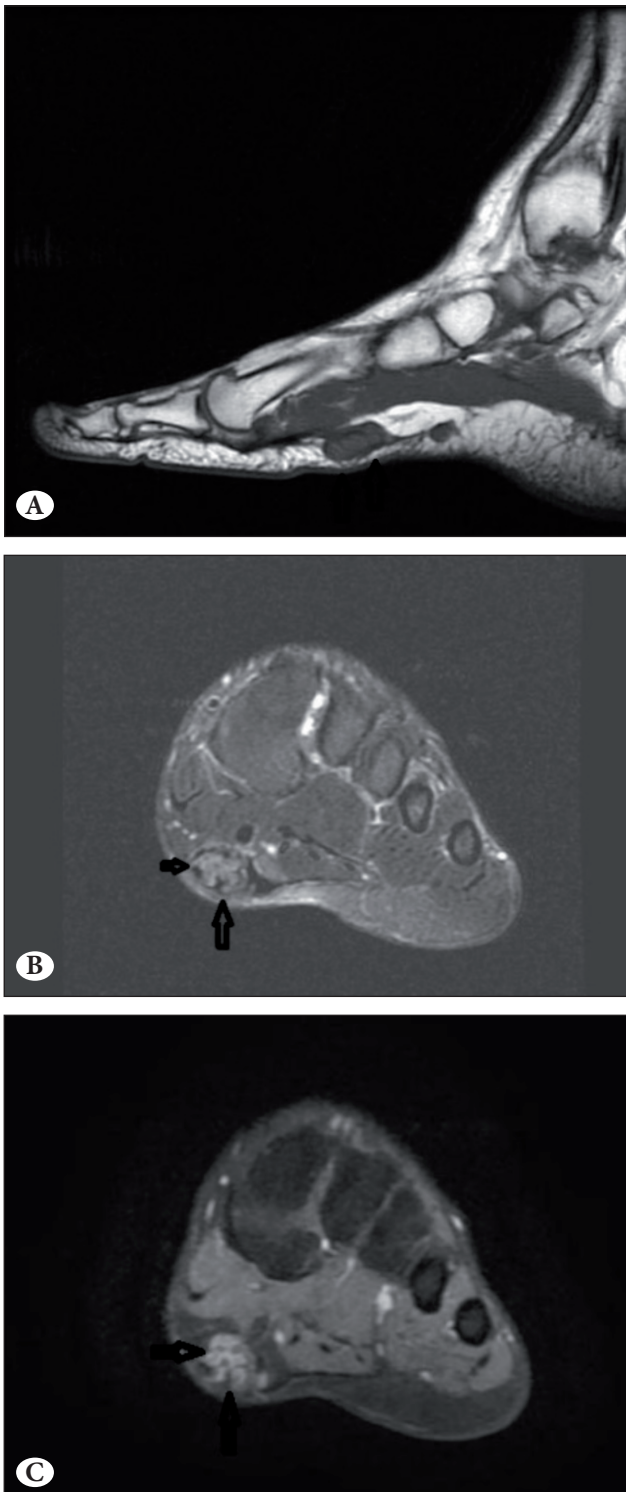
A) Sagittal T1- weighted image B) Coronal T2-weighted fat-suppressed image C) Coronal T1-weighted fat-suppressed contrast- enhanced image show heterogeneously enhancing lesion in the plantar aponeurosis.
